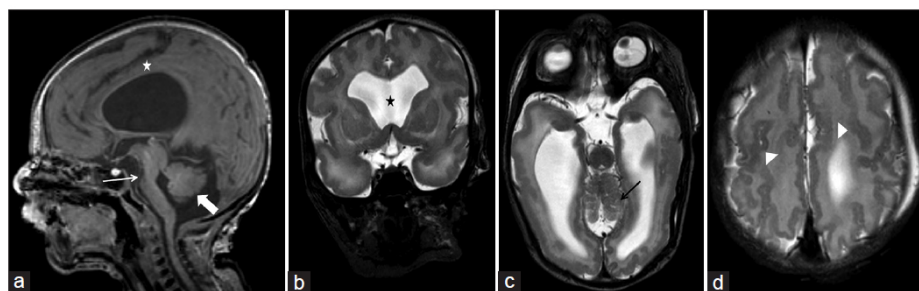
Sagittal T1 (a), coronal (b) and axial (c, d) T2 sections of MRI showing markedly hypoplastic pons with small ventral cleft giving “Z”-shaped appearance to brainstem (white arrow), hypoplastic corpus callosum (white asterisk), absence of the septum pellucidum (black asterisk), hypoplastic cerebellum (white block arrow) with few microcysts (black arrow) and cobblestone lissencephaly in bilateral frontal and perisylvian regions (white arrowheads). The imaging findings are suggestive of a diagnosis of an alpha dystroglycanopathy
